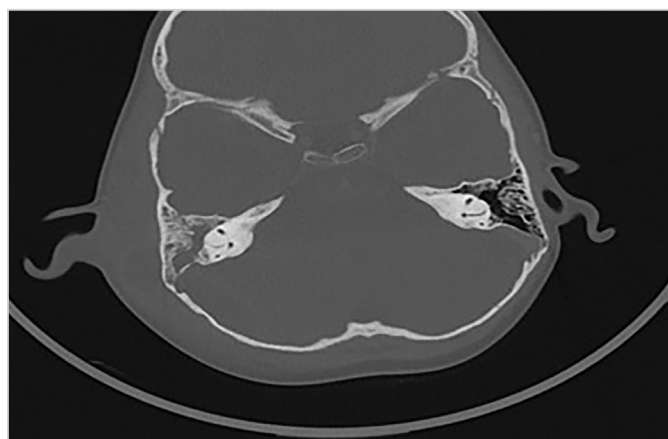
CT scan of a 3-year-old patient with acute mastoiditis complicated by a subperiosteal abscess in the right ear (axial plane) CT: Computed tomography
